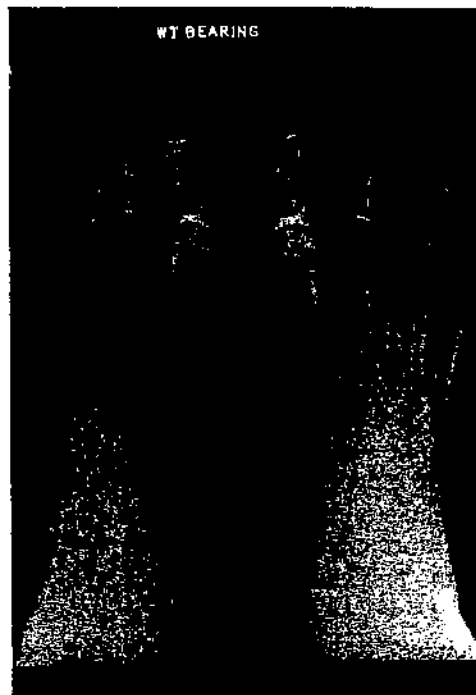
AP radiograph demonstrating slight widening of the joint between the medial and intermediate cuneiform bones. Note that the tarsometatarsal joints are normal.
